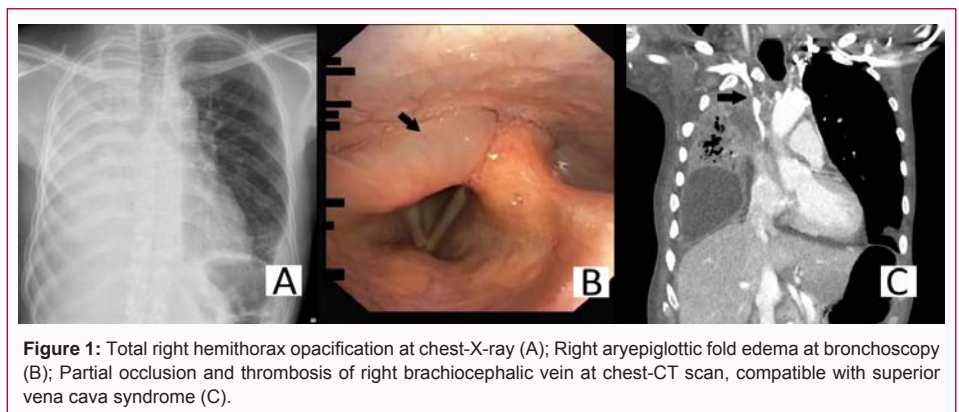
Total right hemithorax opacification at chest-X-ray (A); Right aryepiglottic fold edema at bronchoscopy (B); Partial occlusion and thrombosis of right brachiocephalic vein at chest-CT scan, compatible with superior vena cava syndrome (C).
